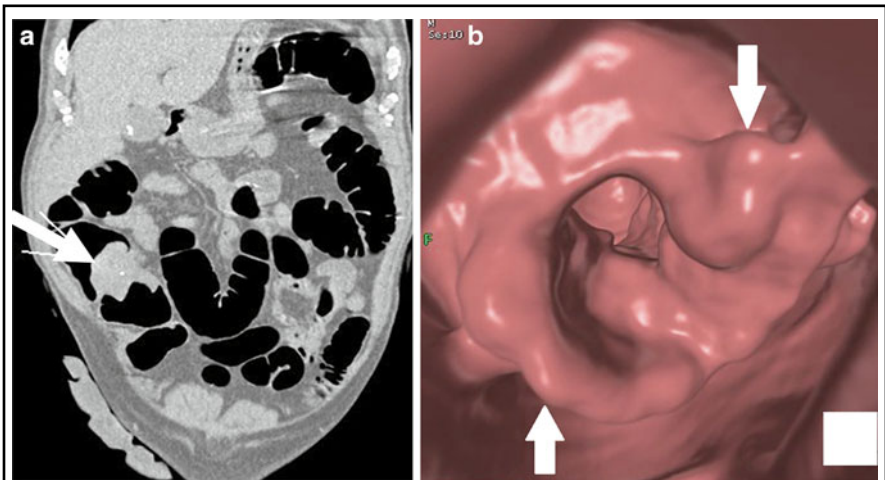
CT COLONOGRAPHY
